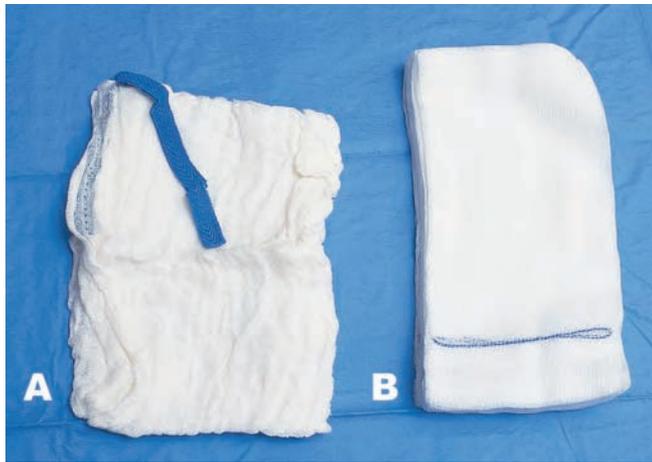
Surgical sponges: (A) Laparotomy, (B) X-ray detectable 4-in. × 4-in. (Ray-tec)
